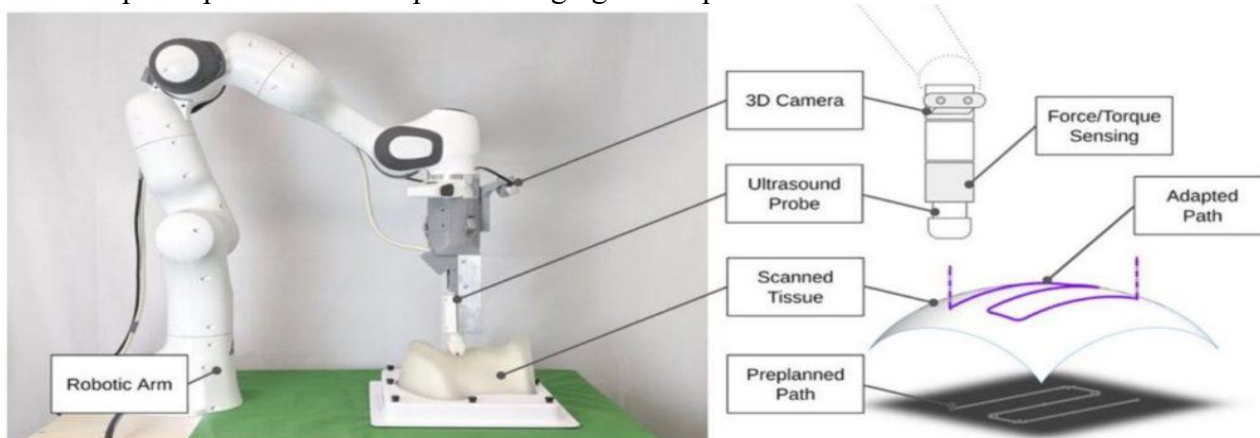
Path inspection of the ultrasound robot
